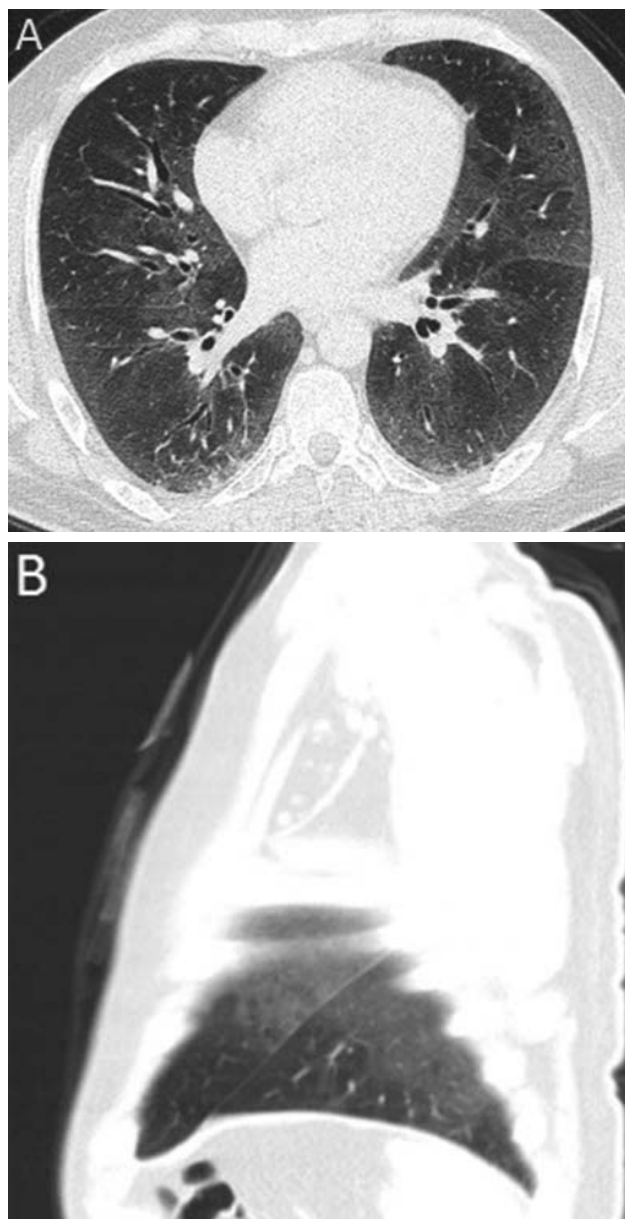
A) Bilateral peripheral, pericardiac and peribronchovascular patchy distribution of GGO areas were observed on axial CT image at the inferior pulmonary vein level. B) Sagittal CT slice shows that costophrenic and cardiophrenic angles are spared.
